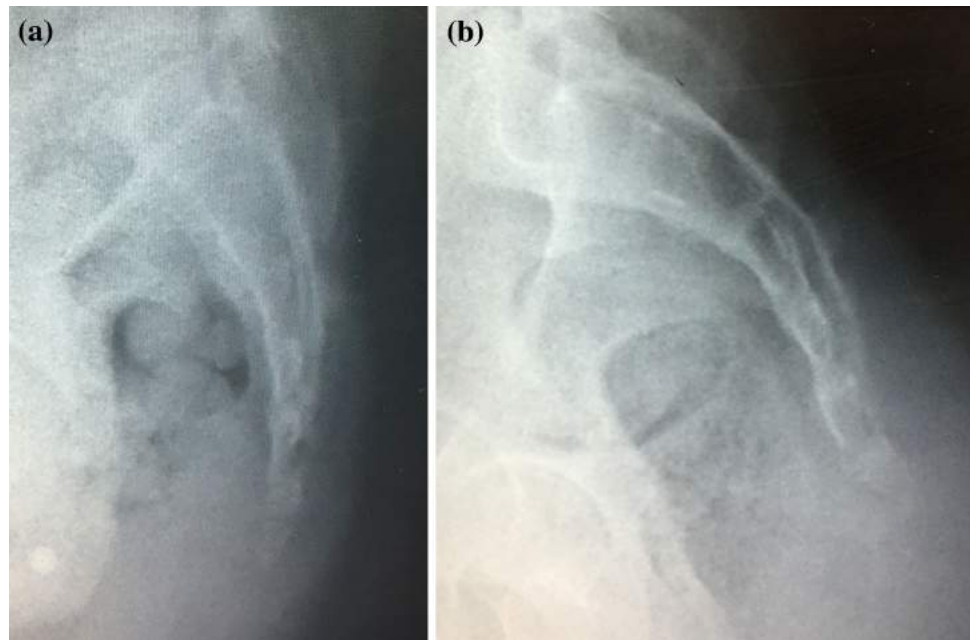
a Lateral standing X-ray of the coccyx of a 36-year-old female with coccydynia showing fusion between the coccygeal segments; b Lateral sitting X-ray of the same patient showing posteriorcoccygeal subluxation; c Lateral X-ray of the coccyx of a 43-year-old male with coccydynia showing posterior subluxation even in a standing view
